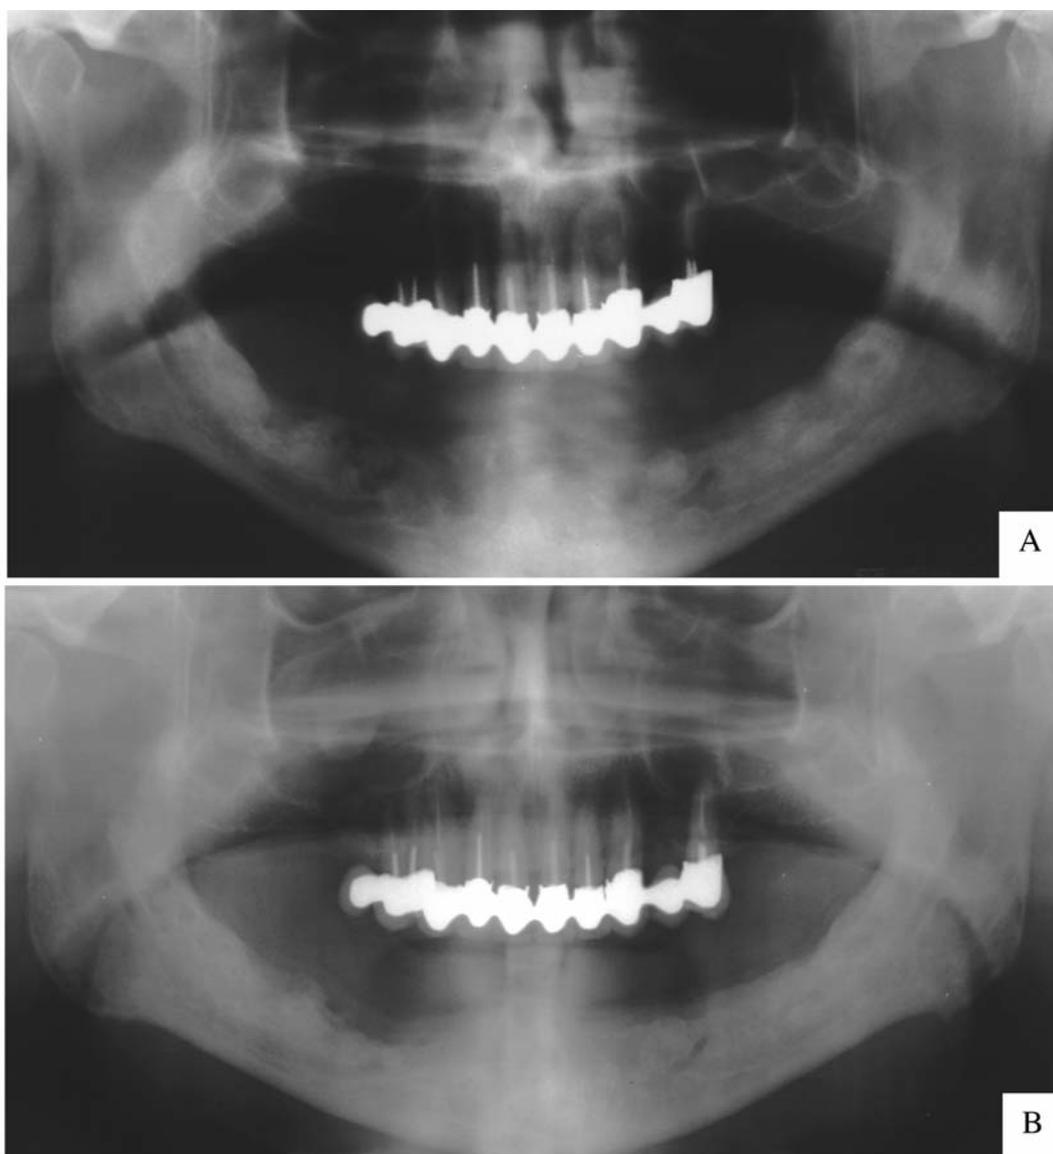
Panoramic X-ray films. A. Pre-operative panoramic radiograph shows multiple radiolucent and sclerotic areas with poorly defined borders in the right mandible extended to the left mandible as well as recent extraction sockets. B. Post-operative panoramic radiograph shows regeneration of the bone and regain of the alveolar bone mass after reconstructive surgery.
